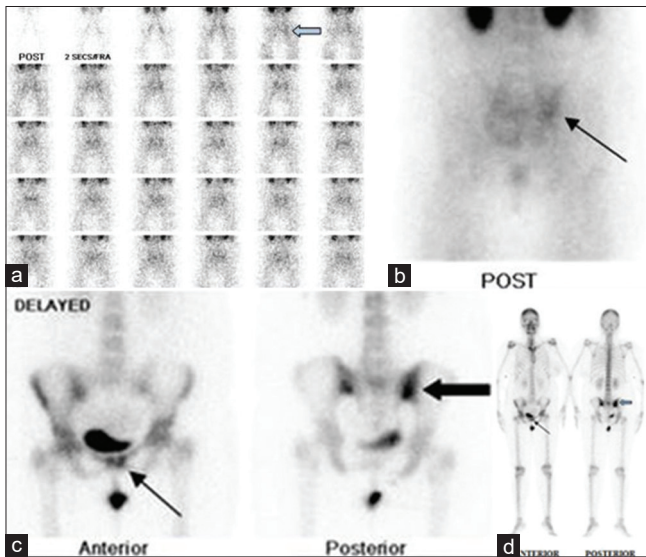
(a) 99mtechnetium-methylene diphosphonate three-phase perfusion-phase skeletal scintigraphy in posterior view shows abnormal perfusion in the region corresponding to the right sacroiliac joint. (b) 99mtechnetium-methylene diphosphonate blood-pool phase scintigraphy in posterior view shows mild tracer pooling in the right sacroiliac region. (c) Increased tracer uptake in the delayed phase seen in the region corresponding to the right sacroiliac region (bold arrow) and symphysis pubis (arrow). (d) 99mtechnetium-methylene diphosphonate delayed whole-body sweep showing increased tracer concentration in the sacroiliac joints (R > L, marked by bold arrow) and mildly increased tracer concentration was seen in the symphysis pubis (arrow). Injection site was noted near the right elbow
